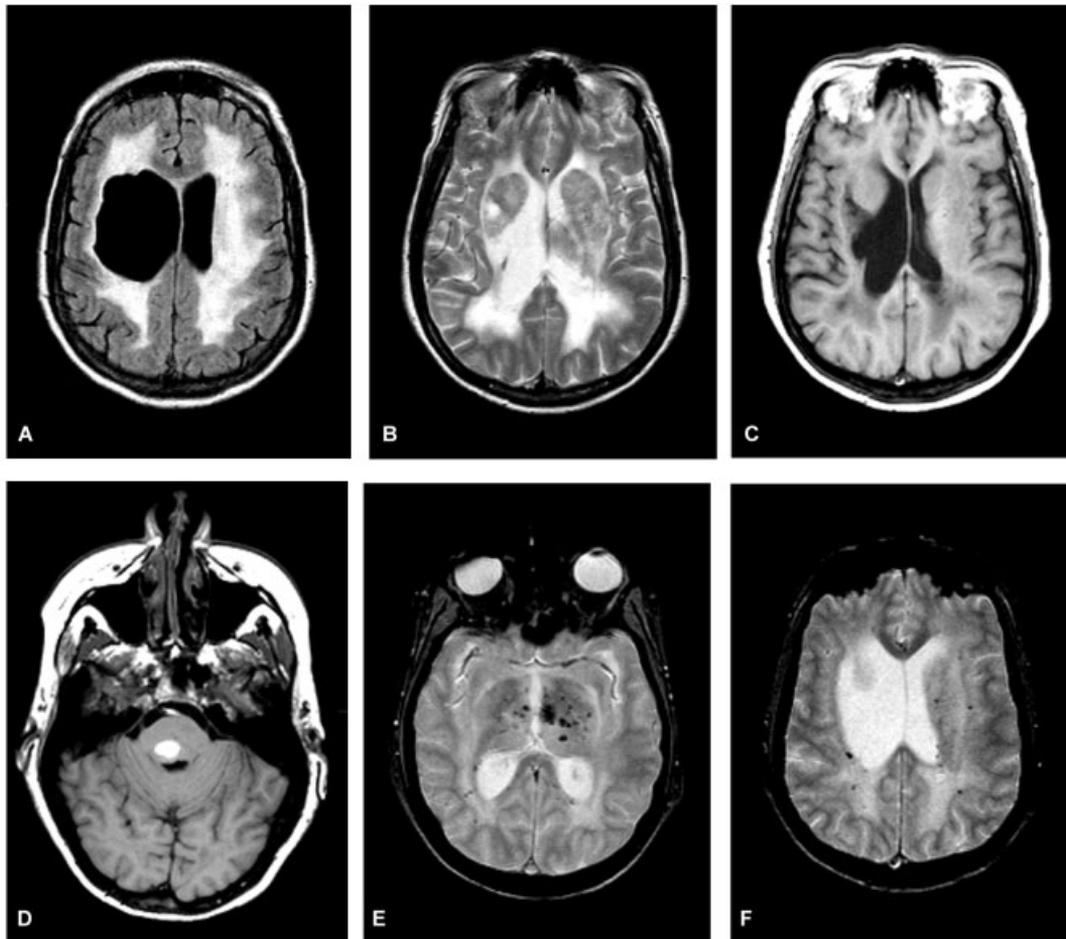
Magnetic resonance imaging of Patient 1 at 47 years old. The axial FLAIR (A) shows a porencephaly on the right and extensive cerebral white abnormalities, relatively sparing the U-fibers. The axial T2-weighted image (B) shows patchy signal abnormalities in the basal ganglia and thalamus. The T1-weighted image at the same level (C) demonstrates multiple small cystic lesions in the basal ganglia and white matter. The T1-weighted image at lower level (D) shows a fresh hemorrhage in the pontine tegmentum. The axial gradient-echo images (E, F) demonstrate many small old hemorrhages spread over the brain, most prominently involving the basal ganglia.
